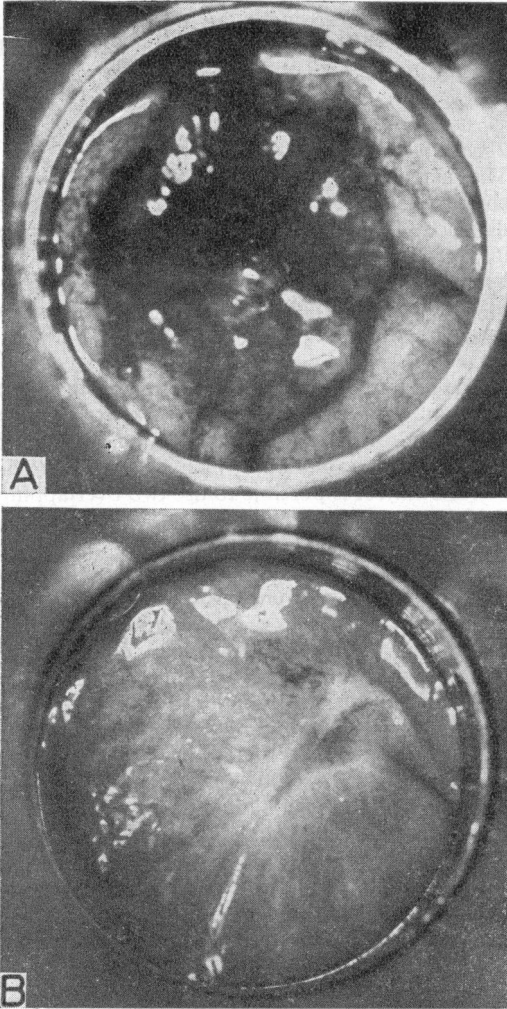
Well-differentiated ulcerative rectal adenocarcinoma, 1 in. (2.5 cm) in diameter, in a 70-year-old woman. A, before endocavitary irradiation. B, after contact X-ray therapy and radium implant. The patient is alive and well after more than 5 years
